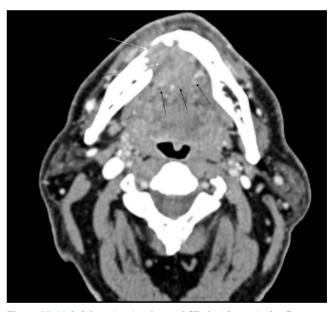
Axial contrast-enhanced CT showing anterior floor of mouth SCC crossing the midline (black arrows) with associated destruction of inner and outer cortex of mandible (white arrows).
